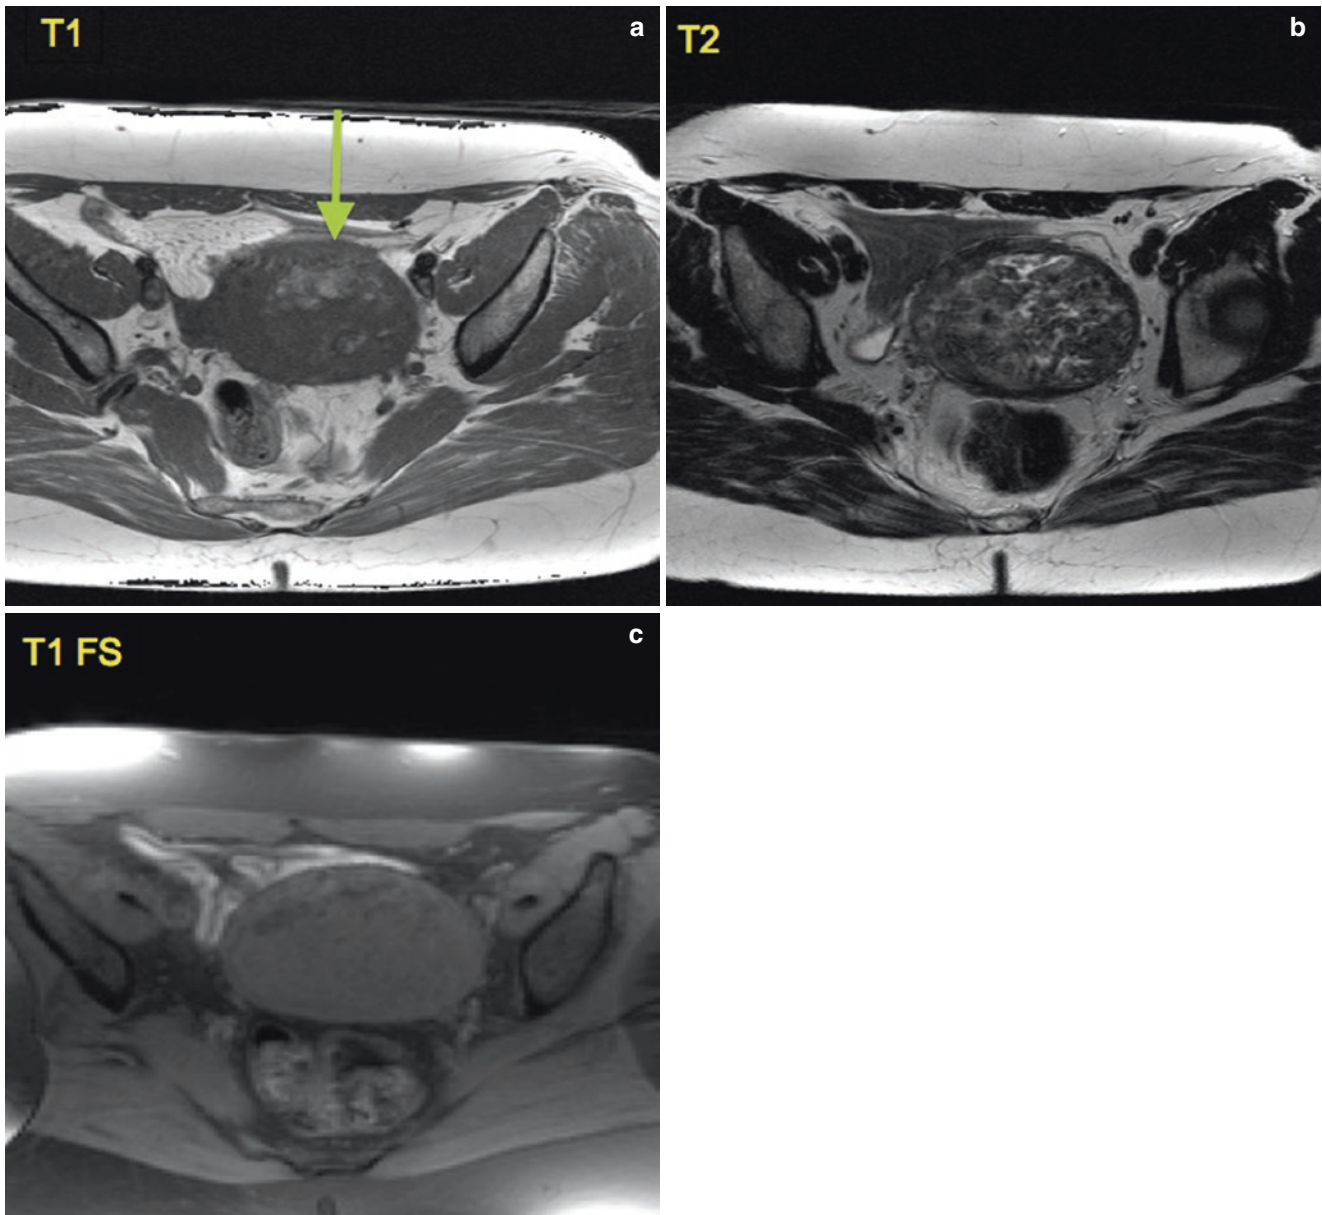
Axial sections of the pelvis MRI, showing a heterogeneous uterine nodule (*arrow*), and with low signal, in images weighted in T1 (a), T2 (b) and with loss of signal in T1 FS (fat saturation – image (c)). This pattern is characteristic of fatty degeneration (lipoleiomyoma)
